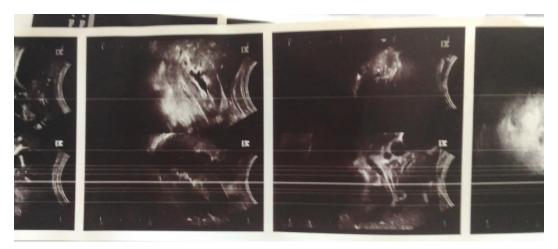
Abdominal ultrasound showed a heterogeneous hyperechoic lesion with necrotic areas in the subhepatic
